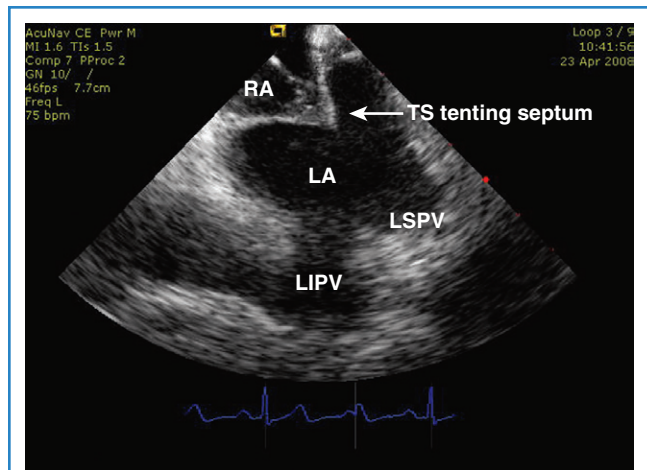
Intracardiac echocardiography image of the atrial septum, left atrium (LA), and proximal left pulmonary veins during trans-septal puncture. Note the trans-septal sheath apparatus (TS) tenting the atrial septum with the left pulmonary veins in the same imaging plane to help cross the septum sufficiently posterior. LIPV, Left inferior pulmonary vein; LSPV, left superior pulmonary vein; RA, right atrium.
